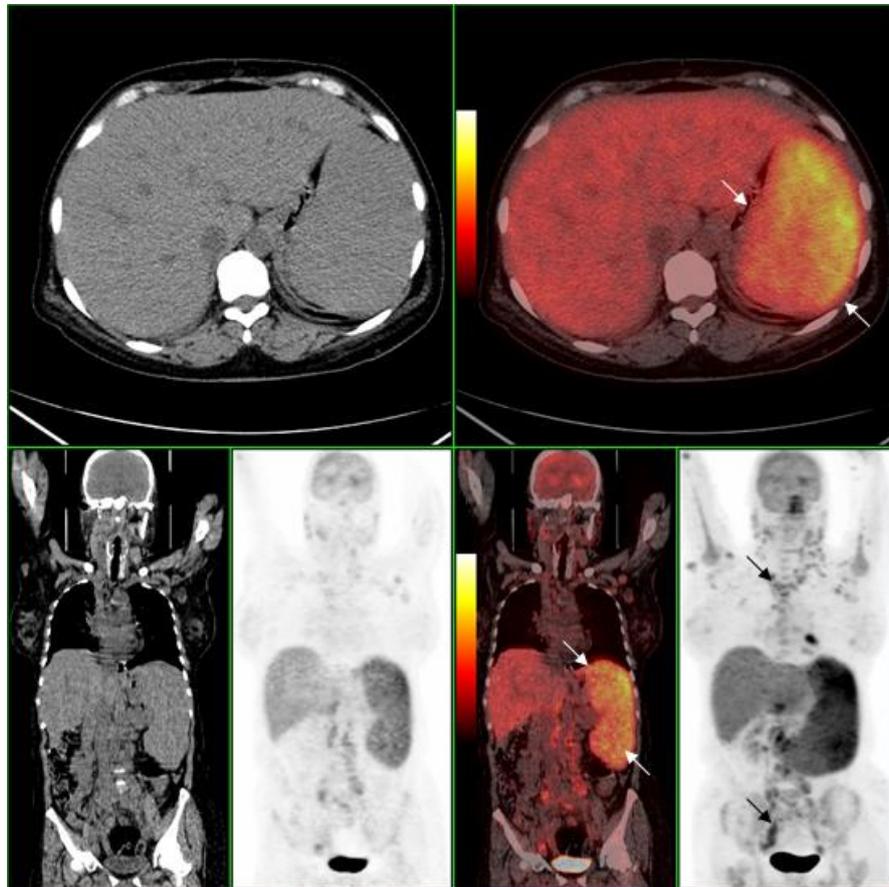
Stage IIIS NHL with splenic involvement in a 54-year-old woman. The axial and coronal ^{18}F -FDG PET image shows diffusely increased splenic uptake of ^{18}F -FDG, which is higher than hepatic uptake (white arrows). The splenic index was 2,126 mL, with S/L ratio of 1.8. Coronal PET/CT and projection images show multiple high metabolism lymph nodes (black arrows) and diffuse splenic hyper-metabolism.
